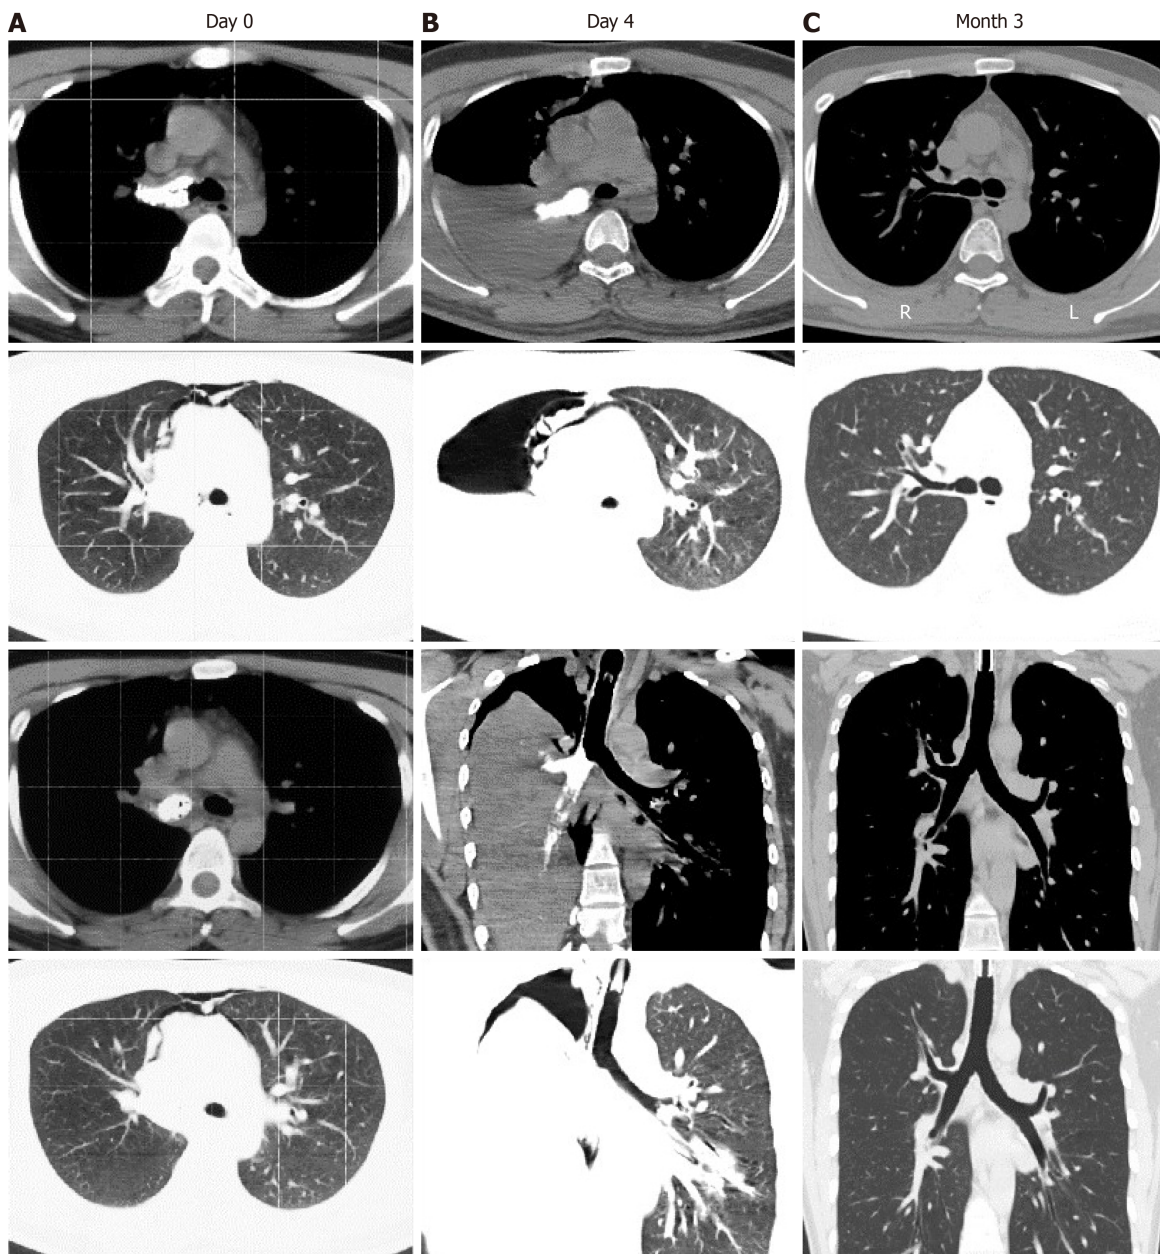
Computed tomography (CT) manifestation of the patient's lung with lime aspiration. A: CT after lime aspiration showed a high-intensity mass in the right principle bronchus, and pneumomediastinum; B: Follow-up CT at 1 d before bronchoscopy showed secondary right pulmonary atelectasis, and aeropleura; C: Follow-up CT at 3 mo showed anatomical recovery of the bronchus and lung.
